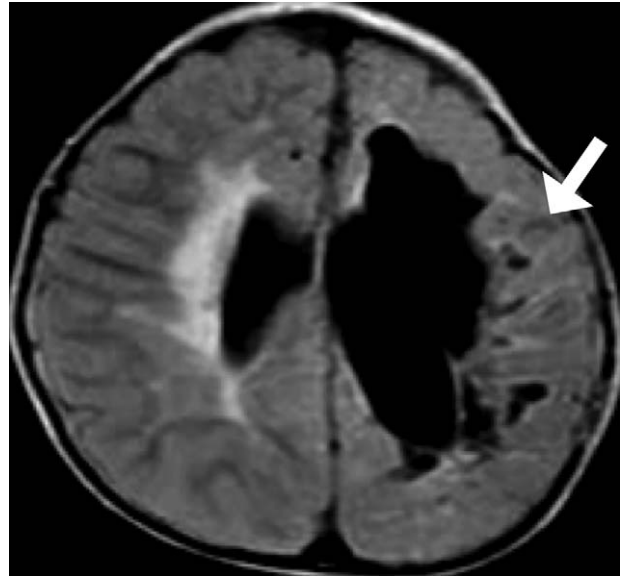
10-Year-old girl with incontinentia pigmenti. Axial T2-FLAIR image shows atrophy and gliosis of the periventricular white matter bilaterally, consistent with sequelae of parenchymal injury, as well as compensatory enlargement of the left lateral ventricle (white arrow).
